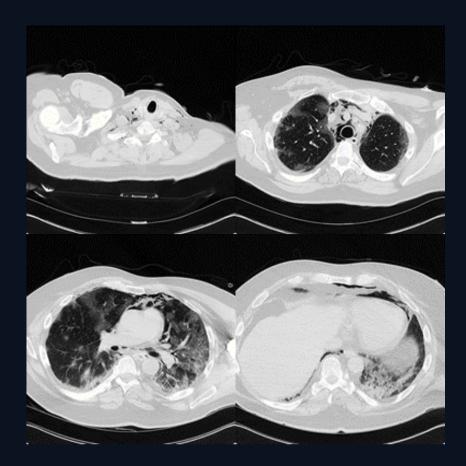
CT Thorax demonstrates multifocal ground glass opacification and consolidation throughout the lungs with peripheral and basal predominance in keeping with the patient's diagnosis of COVID-19 pneumonia. Additionally, pneumomediastinum and subcutaneous emphysema is seen as multiple locules of air in the mediastinum extending to the lower neck. No pneumothorax or interstitial emphysema is evident.
